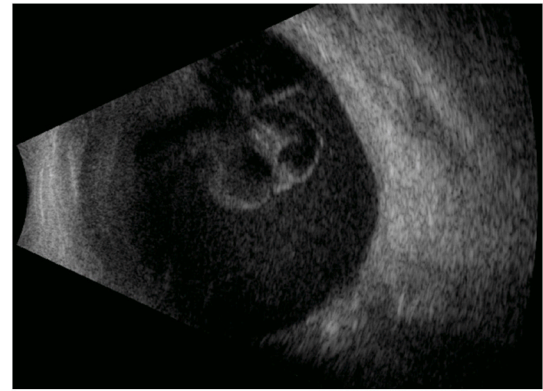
Patient 1: B scan ultrasound scan showing dense vitreous opacities.
